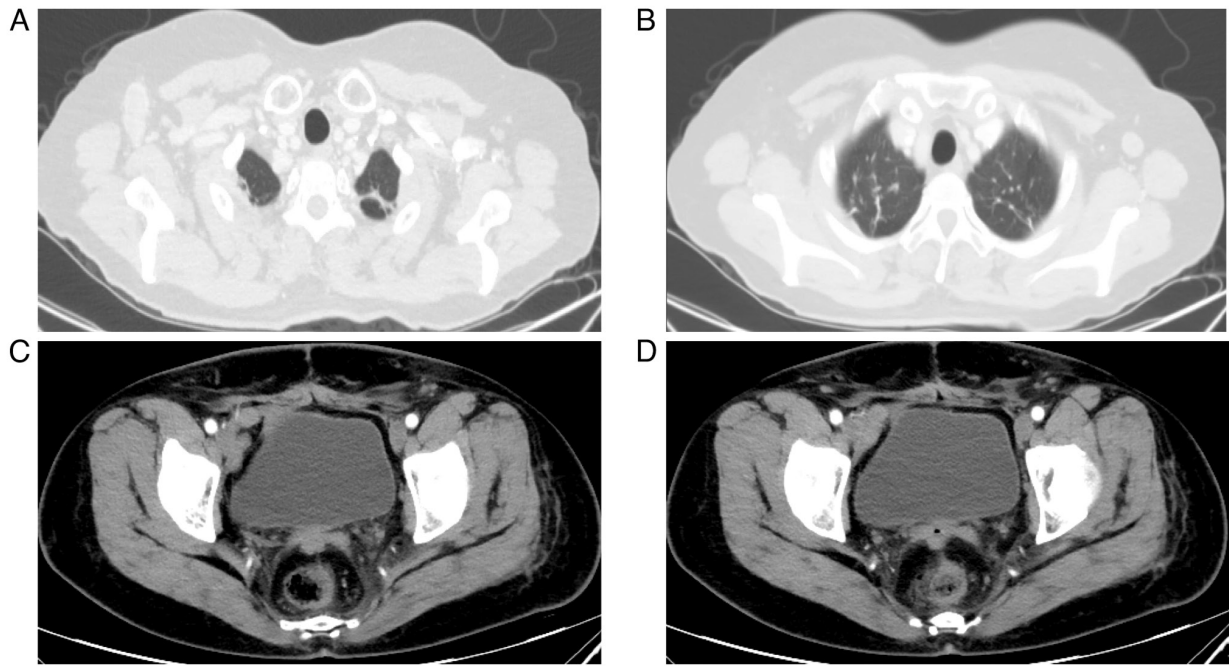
CT images of the patient's recurrence. (A) Shows the patient's right axillary lymph node enlargement, and (B) the left axillary lymph node enlargement. (C) Shows a poorly defined boundary on the posterior bladder wall of the vaginal stump and slightly swollen rectal wall, and (D) shows an enhanced nodule on the posterior wall of the vaginal stump.
